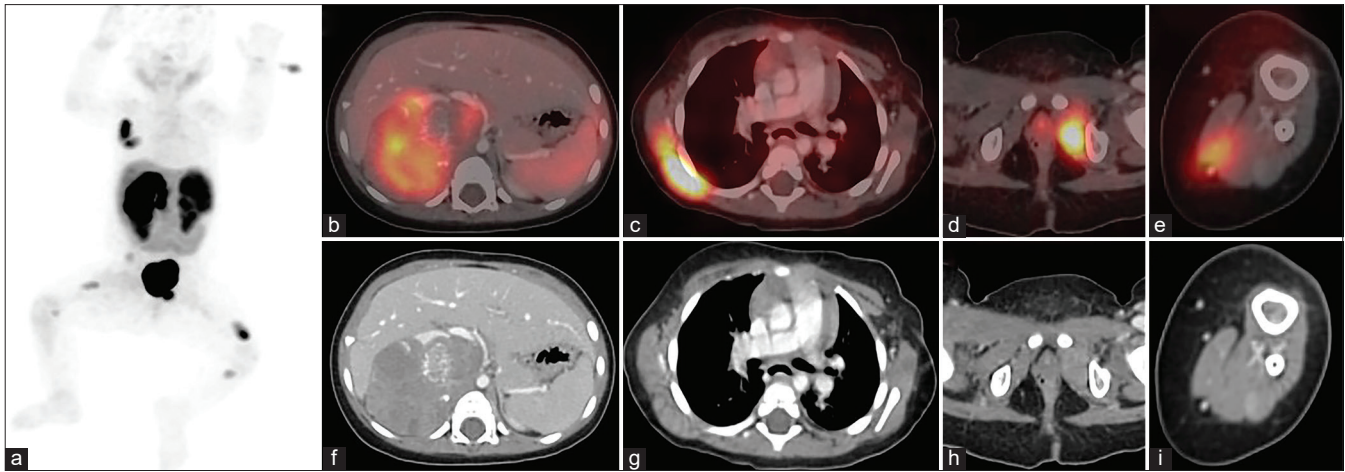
An 1-year-old female baby presented with swelling in the right thigh for 1 month, which was insidious in onset and nonprogressive in nature. The baby had no significant medical history previously. On examination, two additional swellings were revealed in the right scapula and the lateral aspect of the left leg region, which were firm in consistency and not attached to the underlying soft tissue or skin. Laboratory investigation revealed no significant findings. Biopsy from the leg revealed poorly differentiated neuroblastoma positive for CD56 and neuron-specific enolase markers. Magnetic resonance imaging of the right thigh showed well-defined spindle-shaped T2-hyperintense and T1-hypointense lesions in the intramuscular plane of the posterolateral aspect of the right upper thigh. The baseline ^{68}Ga -DOTANOC positron emission tomography/computed tomography (PET/CT) for staging, maximum intensity projection (a), and transaxial CT and fused PET/CT sections revealed heterogeneously tracer avid enhancing lobulated right suprarenal mass (b and f) with areas of calcifications measuring 10 cm \times 7 cm with multiple retroperitoneal lymph nodes. Interestingly, the right infraspinalus and teres minor (c and g), left obturator (d and h), left rectus femoris, and left gastrocnemius (e and i) intramuscular deposits and right iliac cortical bone deposits were visualized
